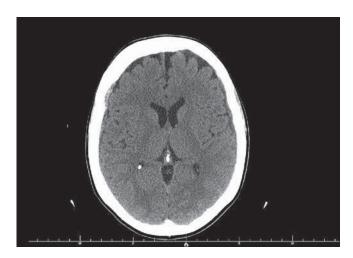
CT head examination: the images show narrow subdural hematoma with the maximum width of 5.5 mm at the frontal lobe and partial spread to the temporal lobe of the right brain.
